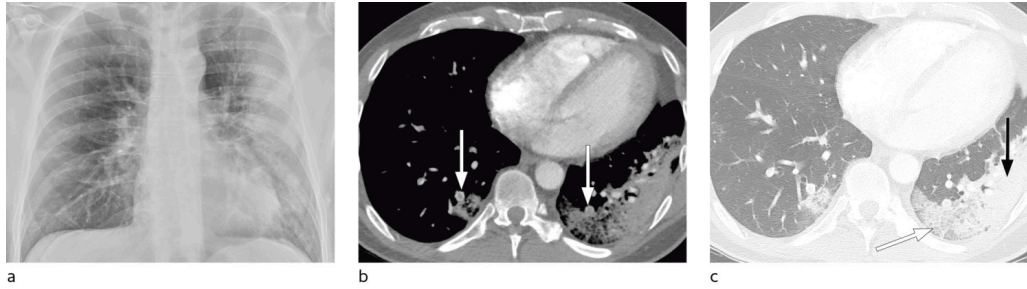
a) Patient with COVID-19 hospitalised because of reduced general condition. Bedside chest X-ray 11 days after symptom onset shows opacities peripherally on the left side, the right lung is normal. b) Clinical suspicion of pulmonary embolism arose 16 days after symptom onset. Chest CT with IV contrast medium shows peripheral pulmonary embolisms bilaterally (white arrows). c) The same section level presented in lung window shows peripheral opacities of both ground-glass type with crazy paving pattern (white arrow) and consolidations (black arrow), most pronounced in the left lung.
